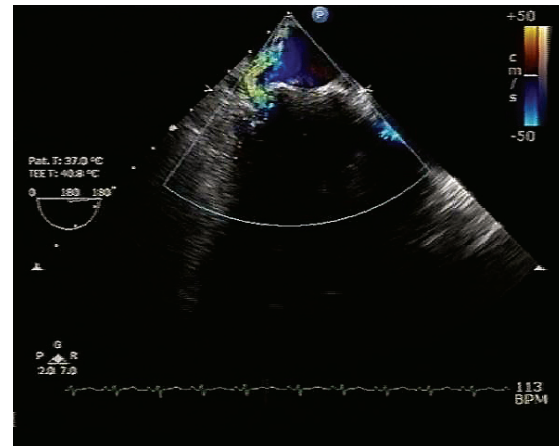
Transoesophageal echocardiogram shows the Starr-Edwards mitral valve prosthesis with paravalvular leak demonstrated on colour Doppler.
